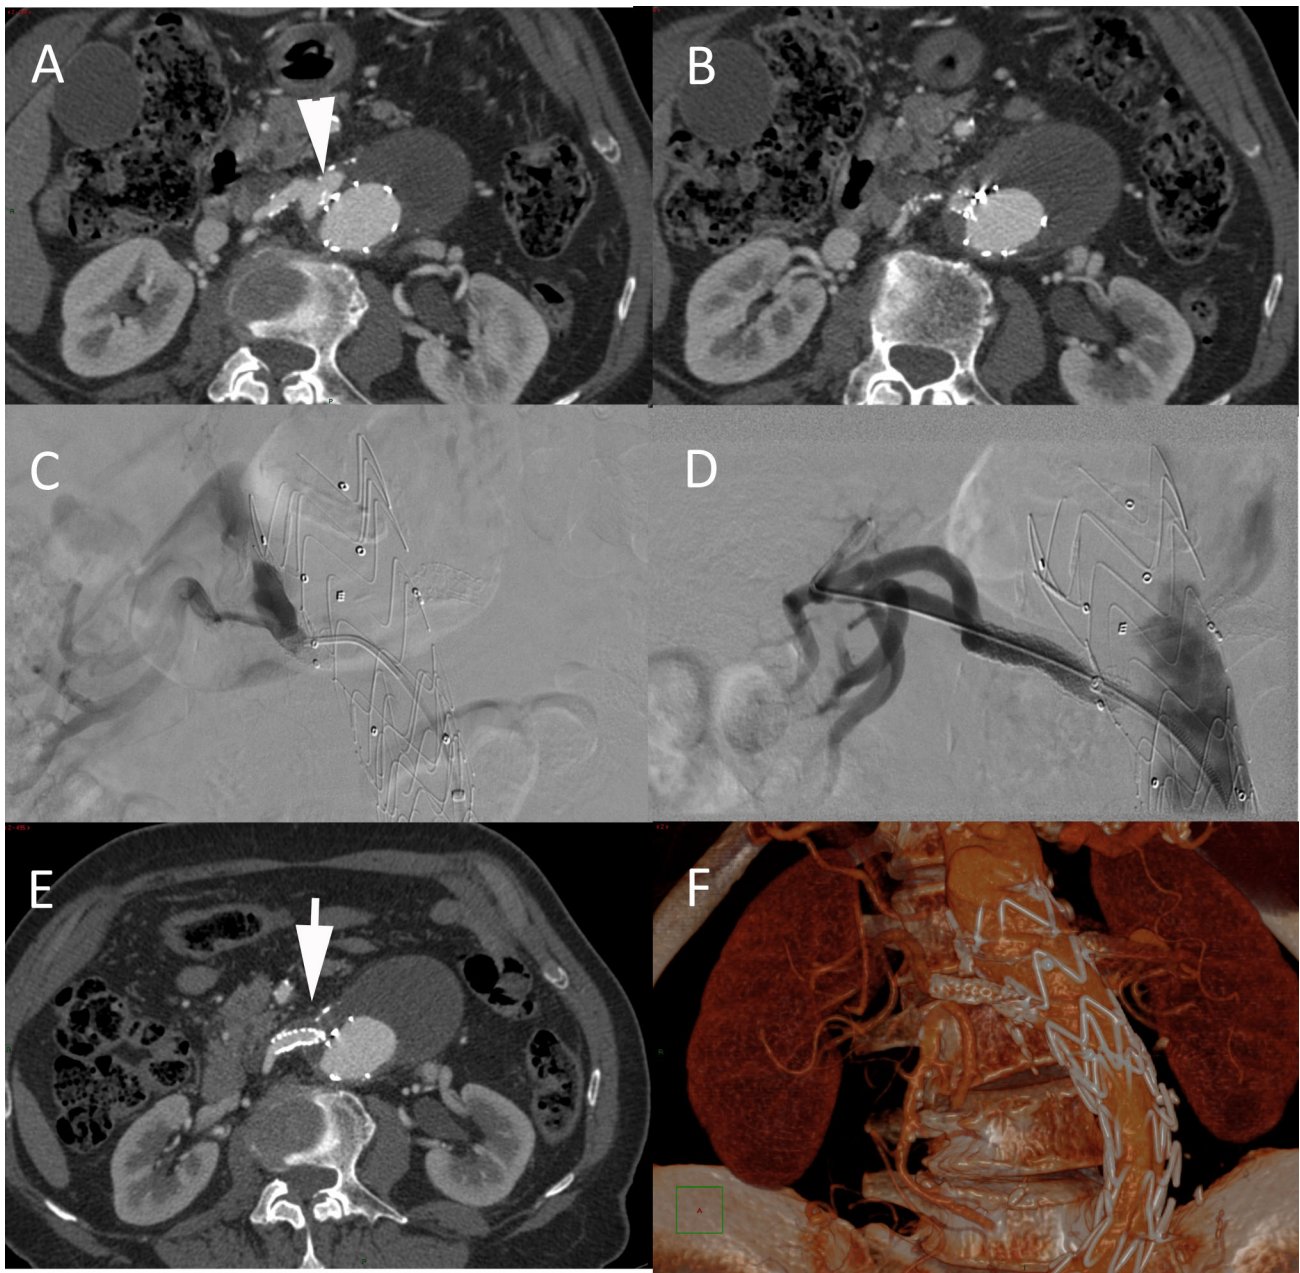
Clinical case of a 69-year-old male patient with a 70-mm Crawford type 4 aneurysm, with the disconnection of the renal fenestration from the right renal artery. A, B Pre-procedural axial CT angiography (CTA) shows disconnection of the right renal stent from the renal artery with concomitant type III endoleak (arrowhead). C Selective digital subtraction angiography (DSA) confirms stent
